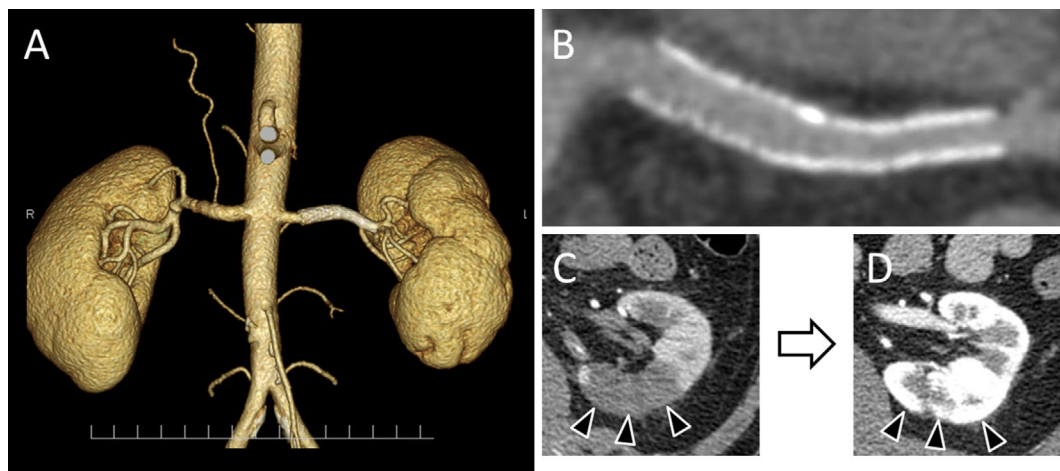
3D CT angiography (A) and curved multiplanar reconstruction image of stented site (B) at six months follow-up. The contrast filling defect at the inferior pole (C) was improved after six months (D).
